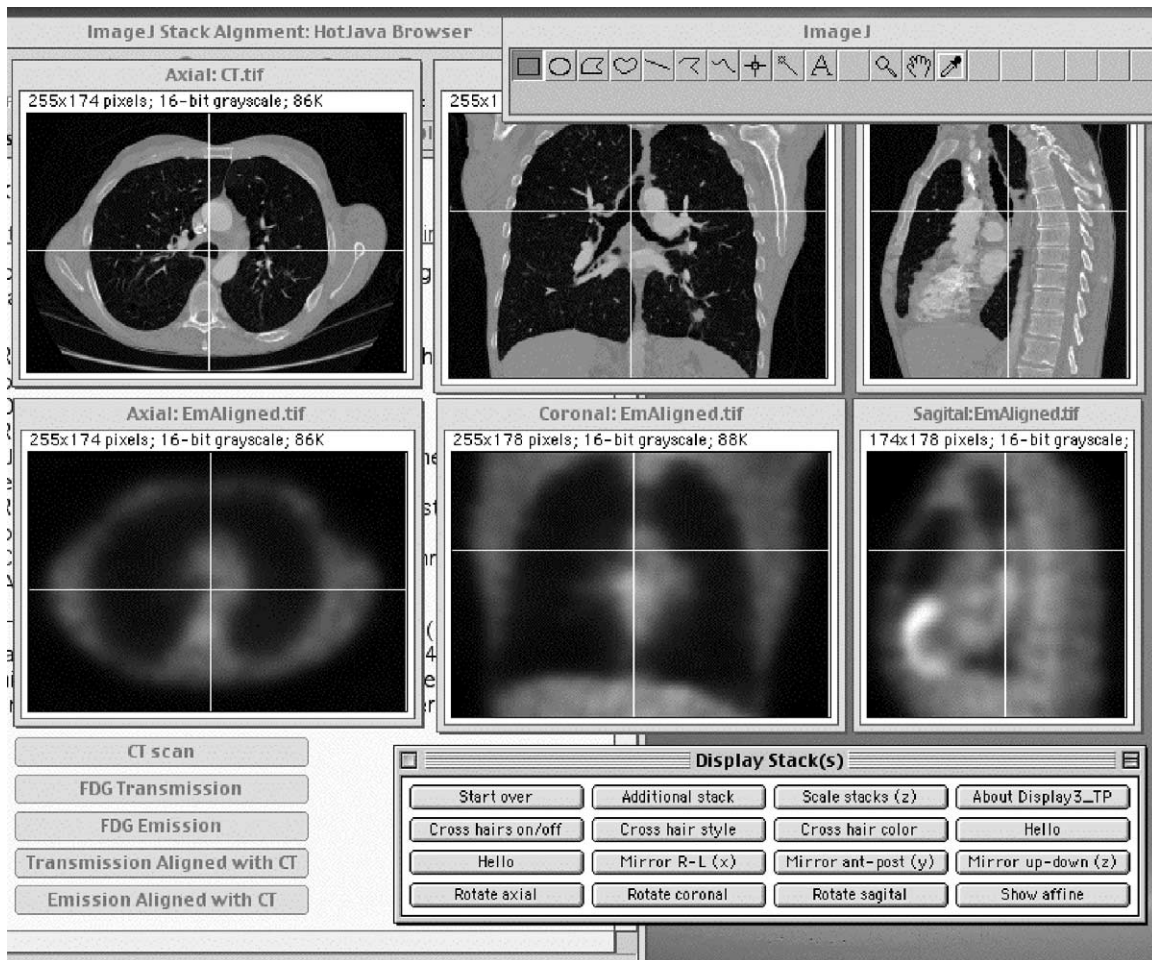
Orthogonal view display by an ImageJ applet. In the background is a web page that is running the ImageJ display program as an applet. The main ImageJ window is the small rectangular panel in the foreground at the upper right corner. Buttons on the web page (visible at the lower left) were used to download a CT and emission fluorodeoxyglucose (FDG) data. The "Display Stacks" window in the foreground controls the orthogonal view display. The user selected the region of the carina on one of the views, and the corresponding orthogonal views from the CT and FDG studies are displayed with linked crosshairs.
